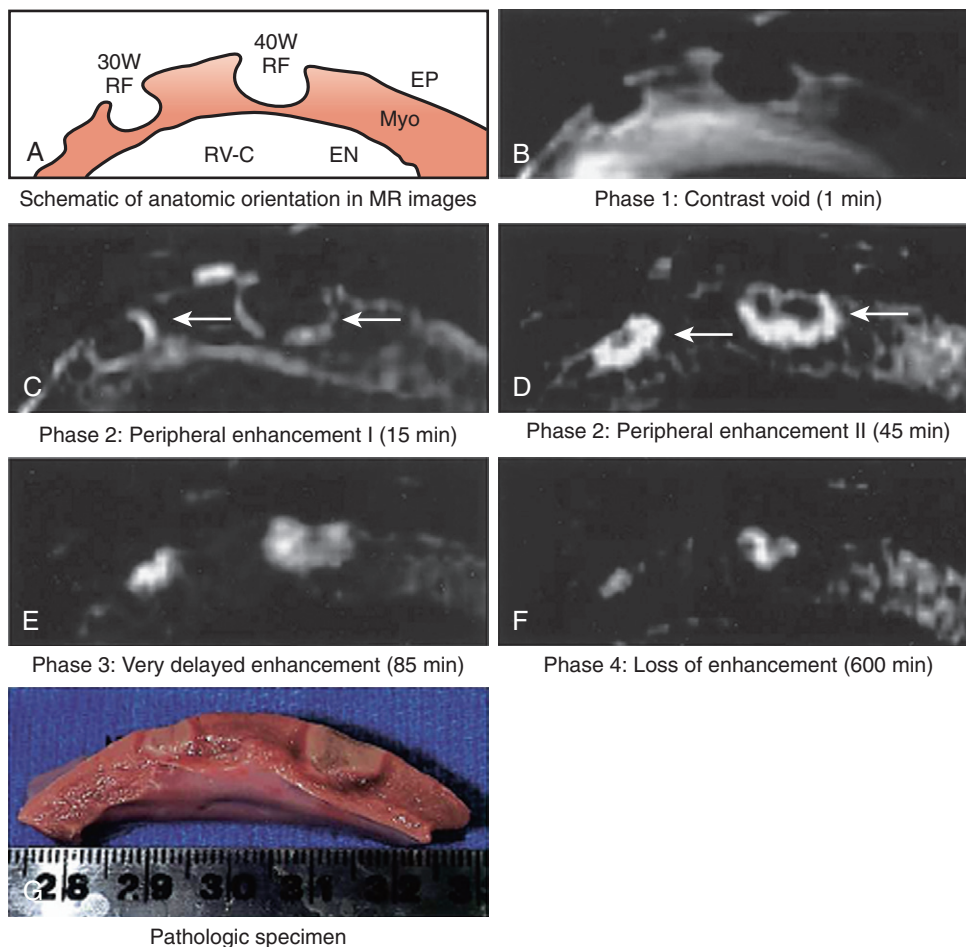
Visualization of radiofrequency ablation lesions using contrast-enhanced magnetic resonance imaging. Immediately after gadolinium injection ablation, lesions can be seen as areas of signal void (B). After increasing peripheral enhancement (C and D), complete “very delayed enhancement” can be seen approximately 90 minutes after contrast injection (E).
